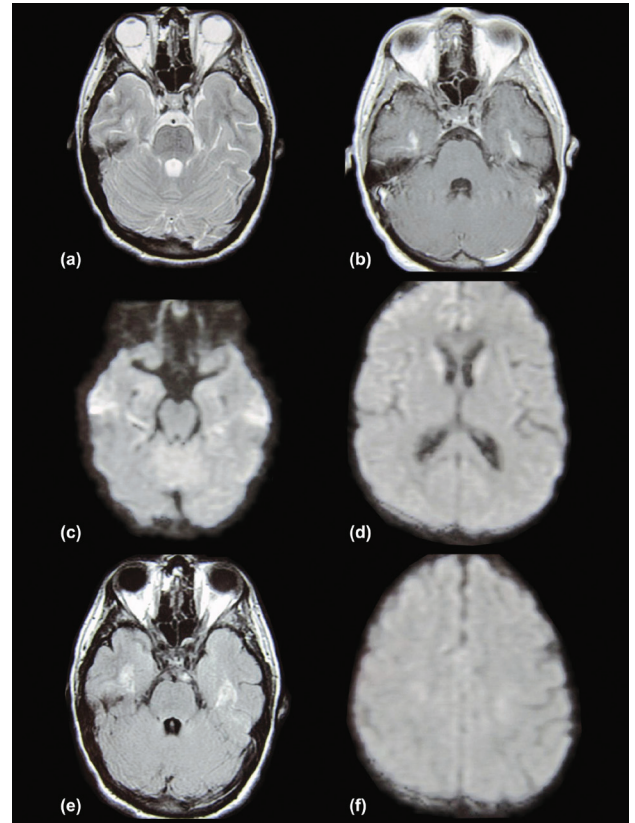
MRI performed after 13 days of hospitalisation: (a) Axial T2W image, (b) Contrast-enhanced axial T1W image, (c) Axial DWI image, (d) Axial DWI image, (e) Axial FLAIR image, (f) Axial DWI image.
